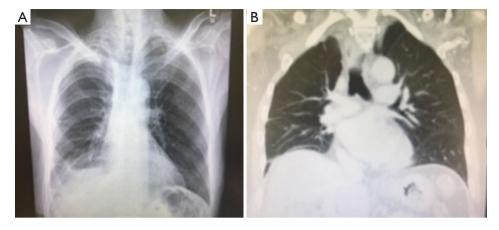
Early and late postoperative chest X-rays. (A) Postoperative chest X-ray of a patient with right pleural mesothelioma who underwent uniportal P/D plus HITHOC following neoadjuvant chemotherapy and was discharged on the third postoperative day. (B) CT chest image 12 months after surgery without signs of recurrence. HITHOC, hyperthermic intrathoracic chemotherapy; P/D, pleurectomy/ decortication; CT, computed tomography.
